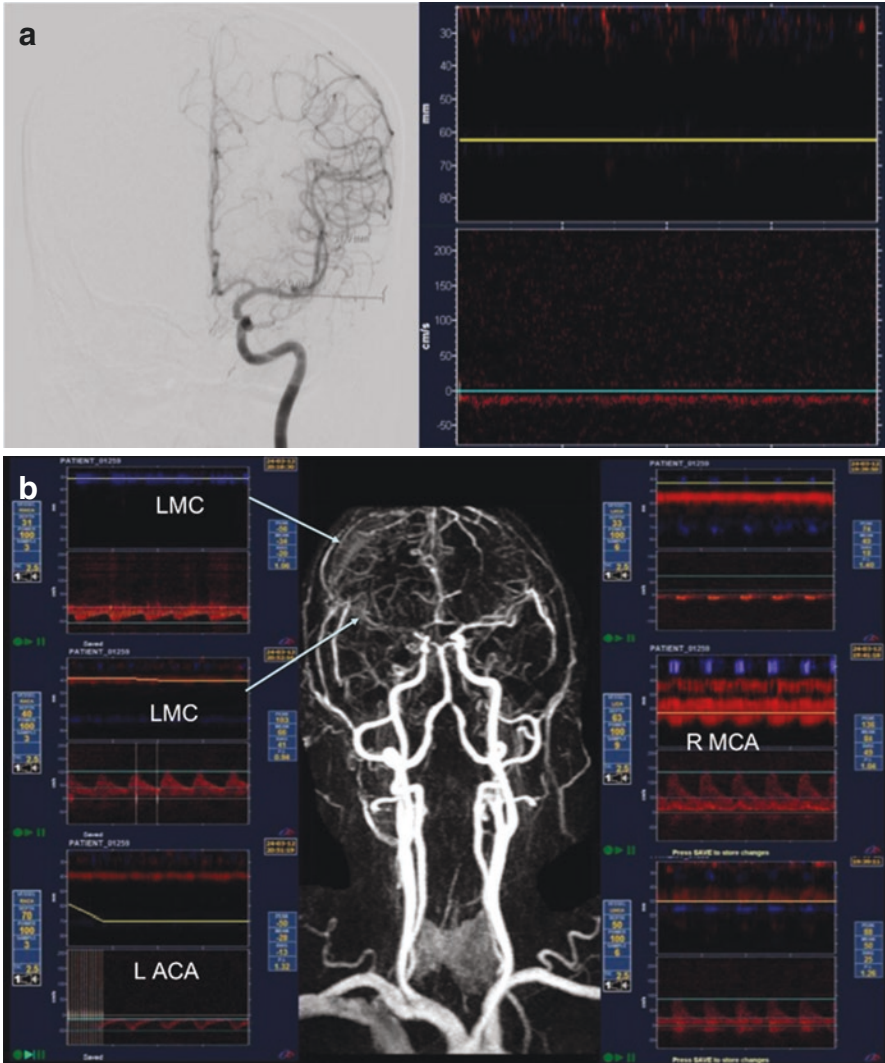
Panel (a) (a) CT angiogram axial sections; (b) Cerebral Angiography: left internal carotid injection; demonstrating the vessels insonated at the depths of 20–40 mm on Transcranial Doppler (TCD); (c) the green and orange horizontal bars demonstrate the depths of 30–40 mm and 20–30 mm respectively on TCD. Panel (b) Right terminal internal carotid artery occlusion, no ipsilateral anterior cerebral artery flow diversion but patient has Leptomeningeal collaterals (LMC) at the depth of 31 mm and 40 mm. R right, L left, MCA middle cerebral artery, ACA anterior cerebral artery
